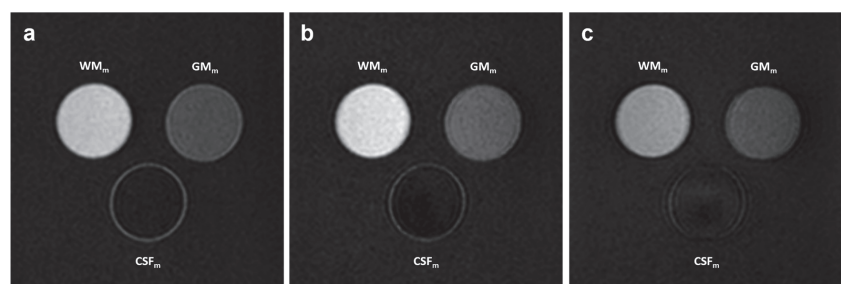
MR images for different TFE factor
